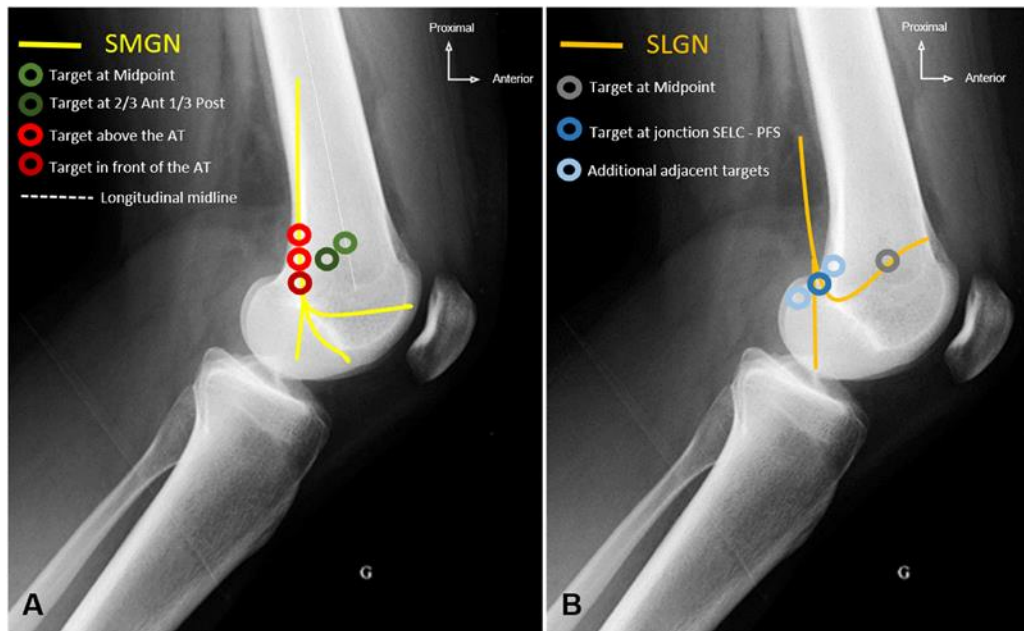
Summary of the different targets with the main course of the nerves, on lateral radiographs. (A) A lesion performed above or just in front of the AT would capture the SMGN whereas classical target would not. (B) Due to the variability of the bony contact of the SLGN, a palisade of lesions (3 blue circles) would improve the capture rate of the SLGN and all its terminal branches. SLGN, superior lateral genicular nerve; SMGN, superior medial genicular nerve.
